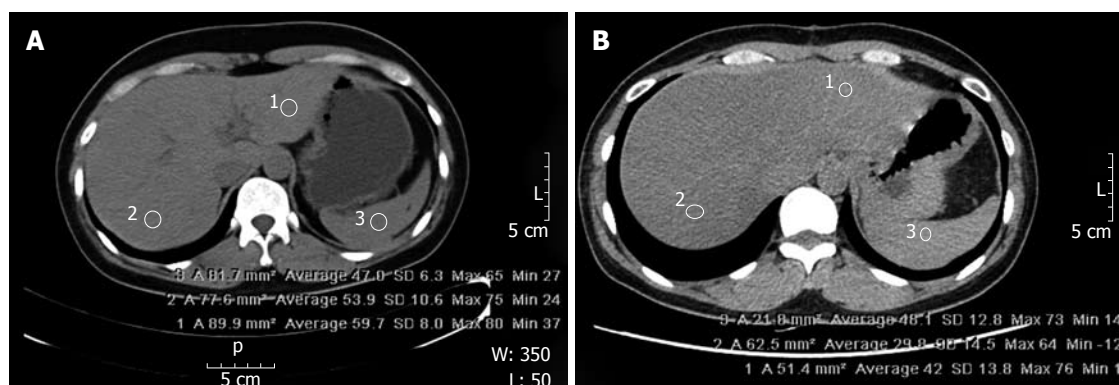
Preoperative and postoperative non-enhanced computed tomography images of a representative patient demonstrating different attenuation values for the spleen and liver. The inclusion criteria were: (1) $CT_{S-L} \geq 10$ Housefield unit (HU); or (2) $CT_{L/S} \leq 0.9$ HU [L: Mean attenuation value for two random points (1, 2) of the liver; S: Attenuation value for one random point (3) of the spleen]. A: Preoperative; B: Postoperative.
